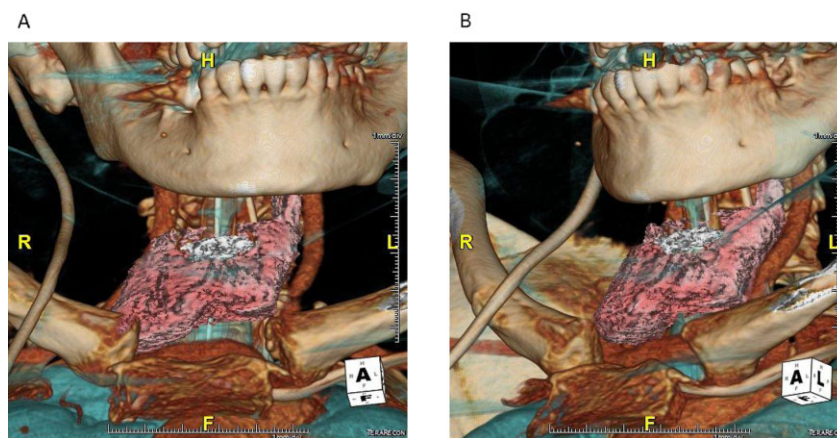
(A, B) Preoperative neck computed tomography reconstruction showing an enlarged thyroid gland overlying the trachea. white: cricoid cartilage; pink: thyroid gland.
